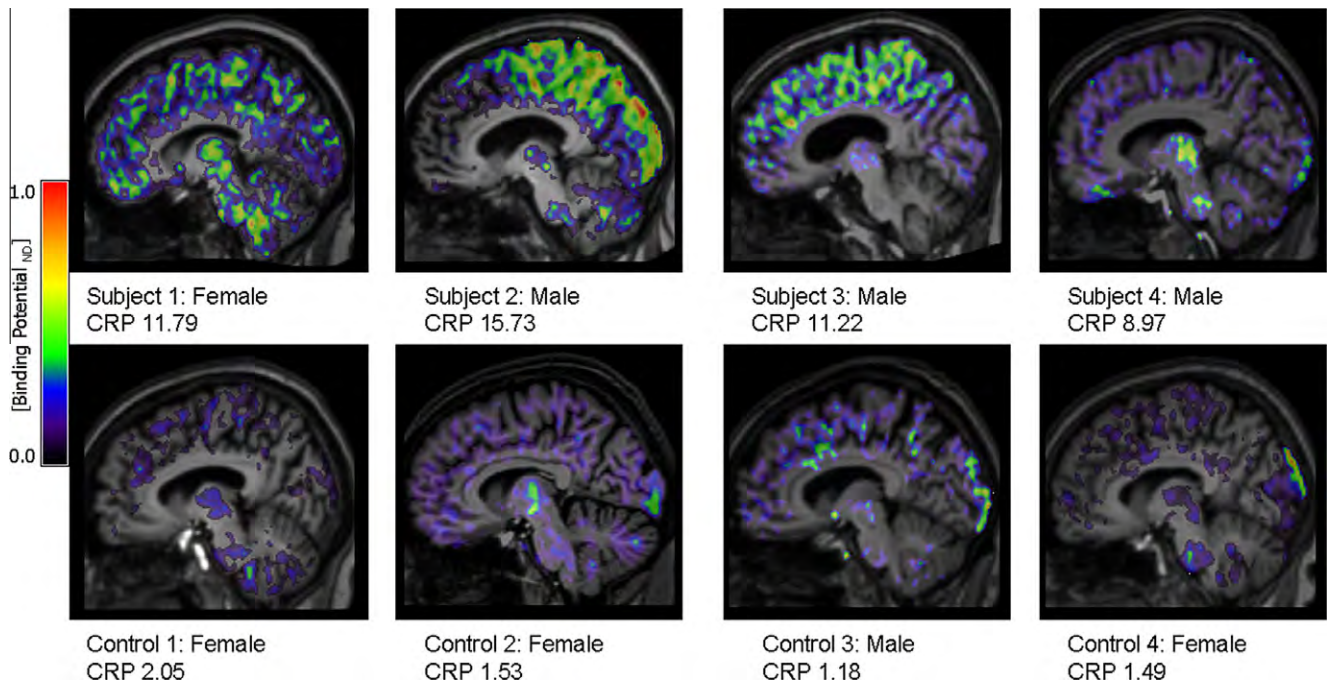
[^{11}C](R)-PK11195 binding potential (BP_{ND}) images are shown for all subjects and control participants. Images are displayed on each subject's respective T1 MRI scan normalised to the SPM5 T1 brain template. The value for each individual's CRP at the time of PET scanning is also shown.
